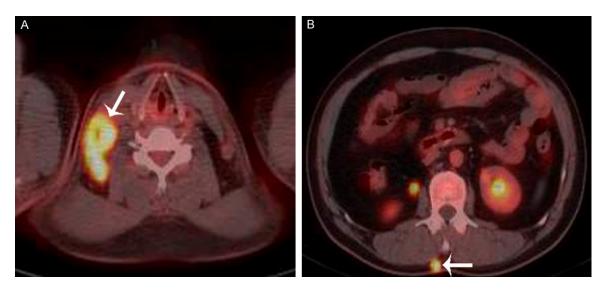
A PET-CT shows the multiple lymph nodes enlargement mass at the right side of the neck root (A). A small mass lesion is seen lying to the back (B).
